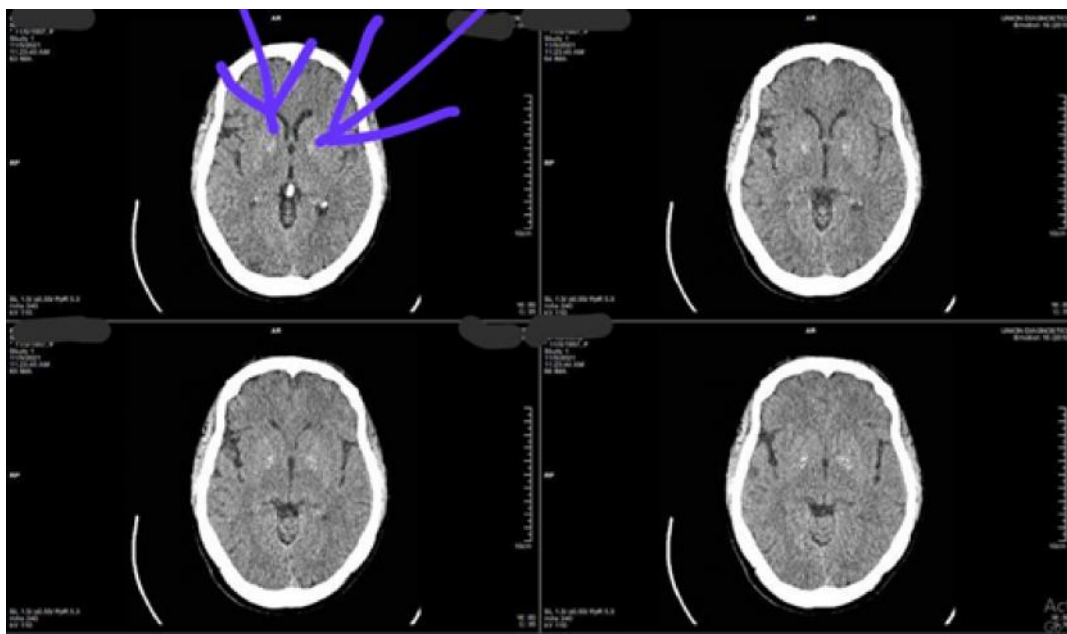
An axial section of the computed tomography (CT) scan of the brain showed hyperdense signals within the Globus pallidi (arrows), the falx and choroid plexus in keeping with calcification (likely age-related)
